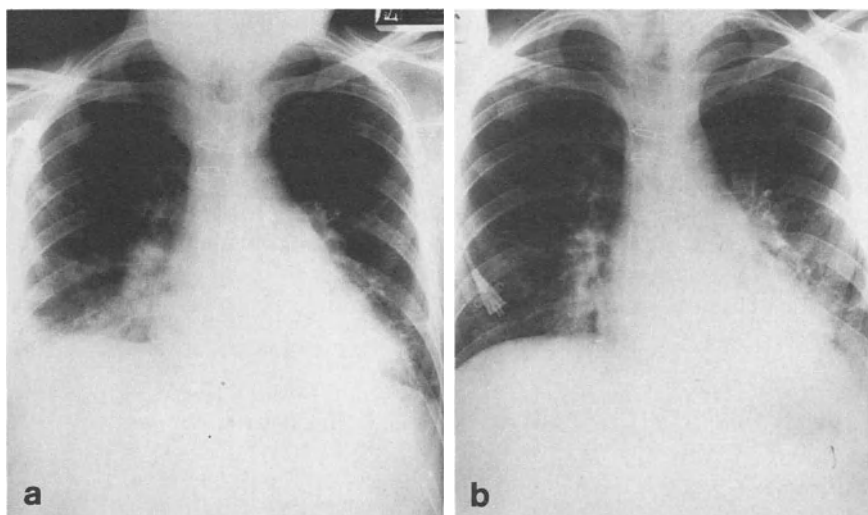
a, b. Chest radiographs from a heart-lung transplant patient during episodes of rejection (a) and cytomegalovirus pneumonia (b), showing similarities in appearance
